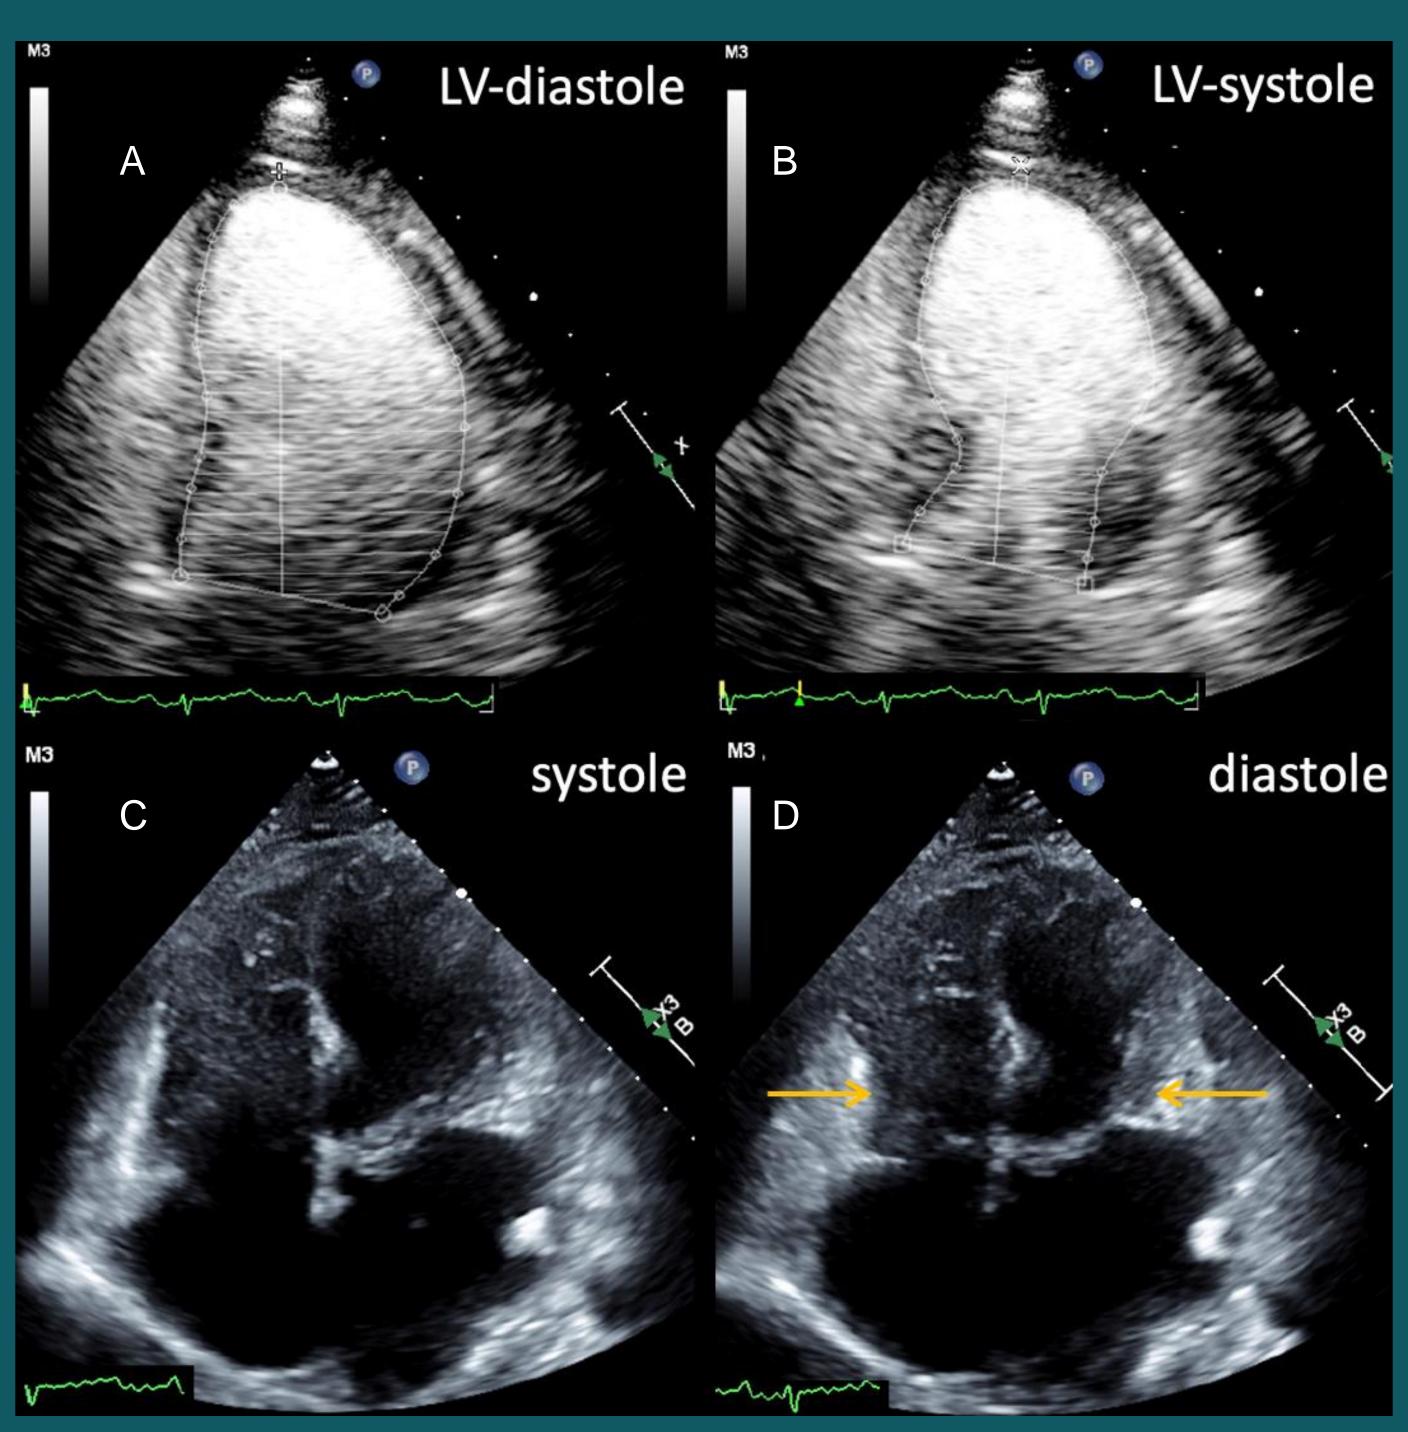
Apical four-chamber view with definity contrast in ventricular diastole (a) and ventricular systole (b) demonstrating severe hypokinesis of mid to apical entire left ventricle with preserved basal contractility. Right ventricle also demonstrates preserved basal contractility with severe hypokinesis of the mid to apical right ventricle (c and d). Differentials include ischemic cardiomyopathy versus severe biventricular stress-induced cardiomyopathy.
